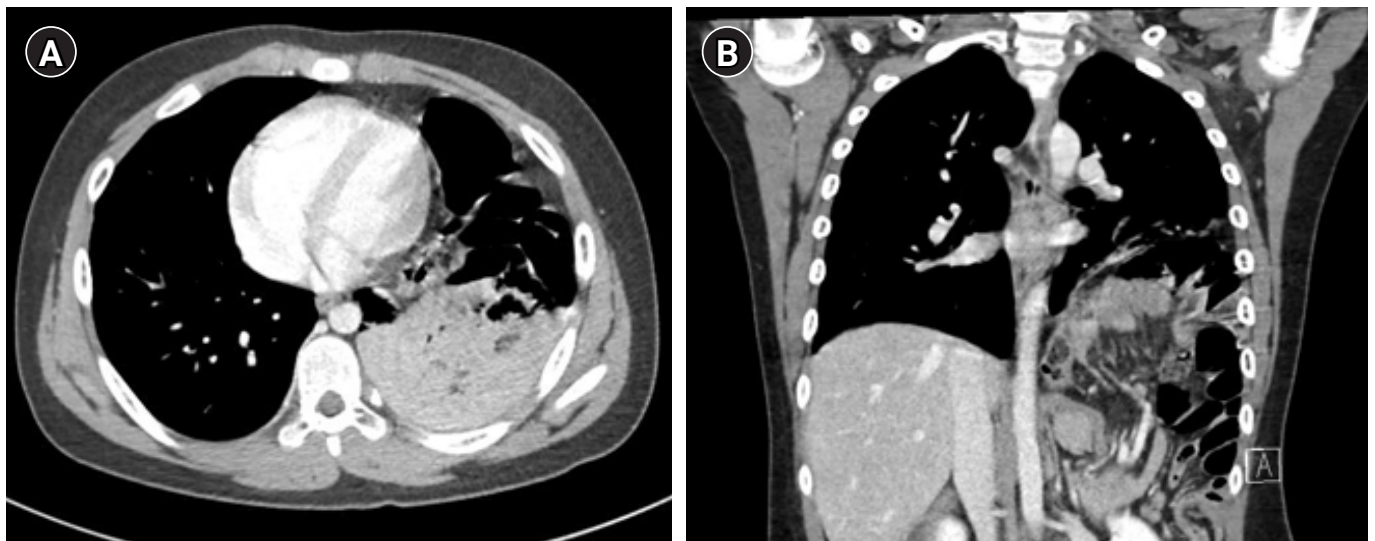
A chest computed tomography (CT) image revealing a diaphragmatic defect in the left side. (A) Preoperative axial thoracic CT image. (B) Preoperative coronal thoracic CT image.
